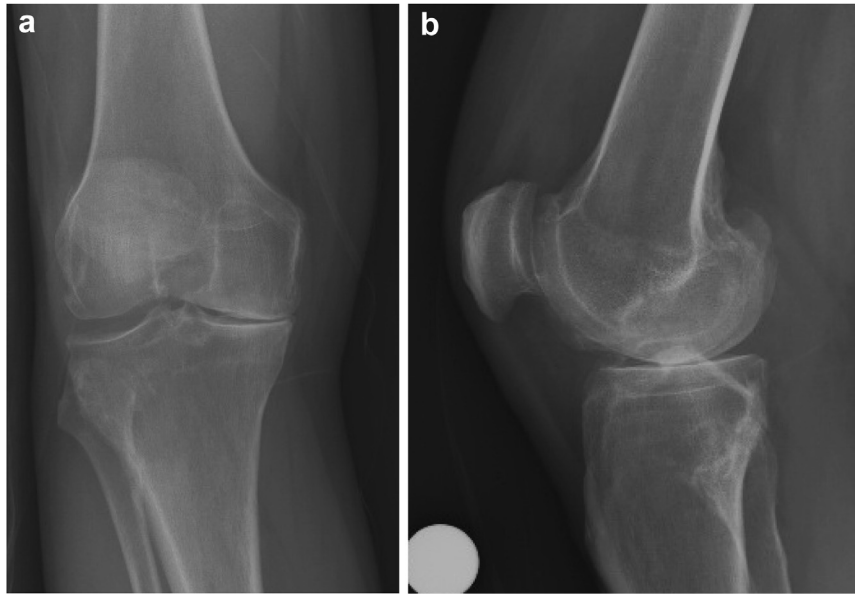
(a) Anteroposterior and (b) lateral plain radiographs of the right knee on presentation demonstrate advanced tricompartmental OA and sclerosis of the PTFJ.
